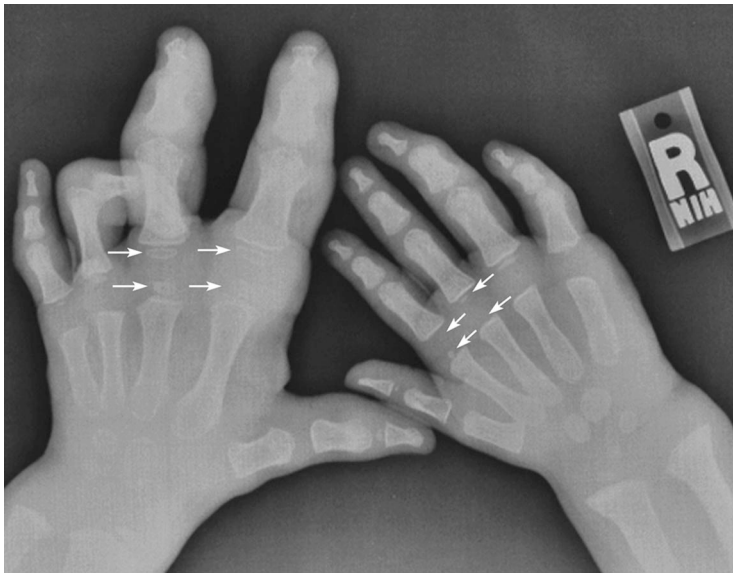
Asymmetric overgrowth and macrodactyly. Posteroanterior radiograph of the hands in a male patient aged 2–3 years shows asymmetric overgrowth of soft tissues and metacarpal and phalangeal bones in the left hand, particularly prominent in the second and third rays, and less prominent macrodactyly in the fourth and fifth rays in the right hand. Note the asymmetry of the ossification centers in the second and third rays (arrows).
